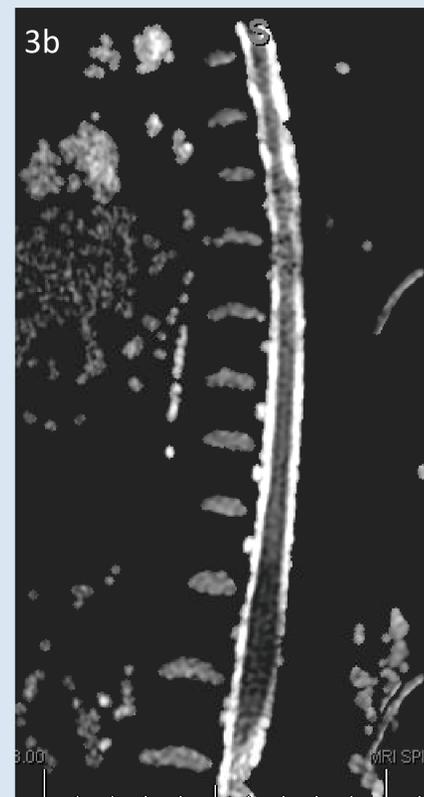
DWI (3a) and ADC (3b) sequence of MRI spinal cord demonstrating diffusion restriction with ADC correlate concerning for spinal cord infarction
